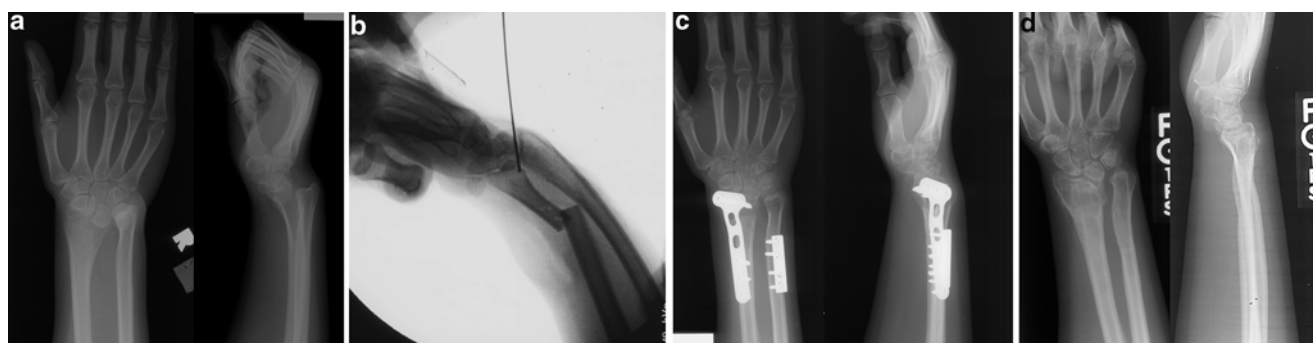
Correction of Madelung deformity via very distal radius osteotomy. (a) Preoperative radiographs. (b) Intraoperative fluoroscopic image. The ulna has been cut and allowed to move into bayonet apposition. A K-wire has been inserted across the radiocarpal joint. (c) Postoperative
